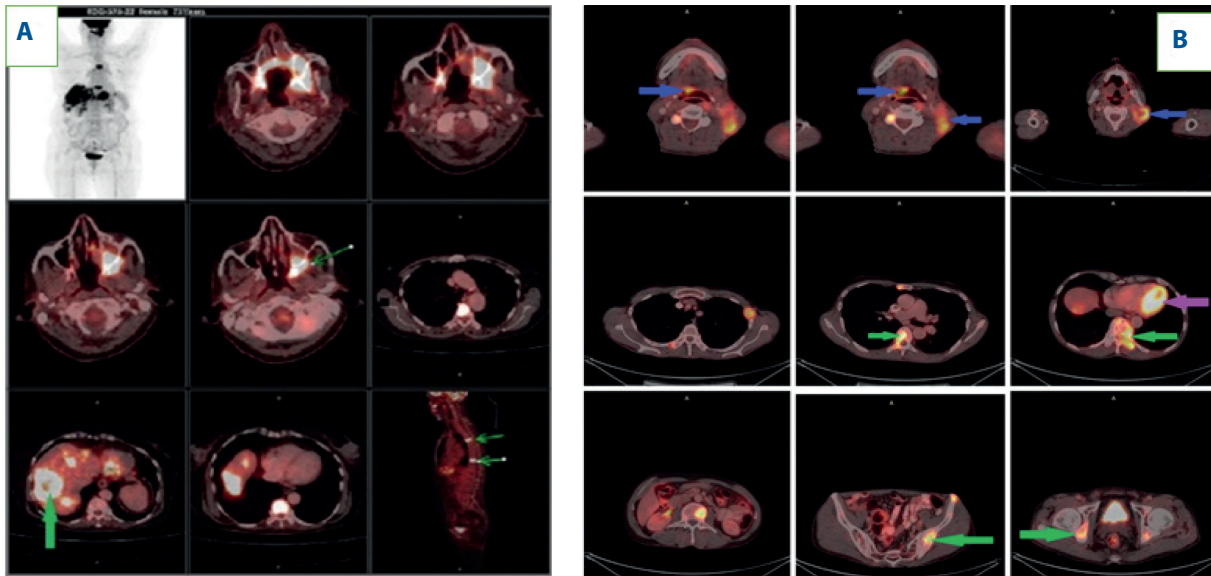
FDG-PET scan showing: (A) vertebral metastasis (D5 and D10, green arrow) in a patient with left maxillary sinus squamous cell carcinoma; (B) metastatic lesions in multiple pelvic bones, vertebra (green arrow) in a patient of base of tongue squamous cell carcinoma (blue arrow). The purple arrow indicates associated liver metastasis in the same patient
